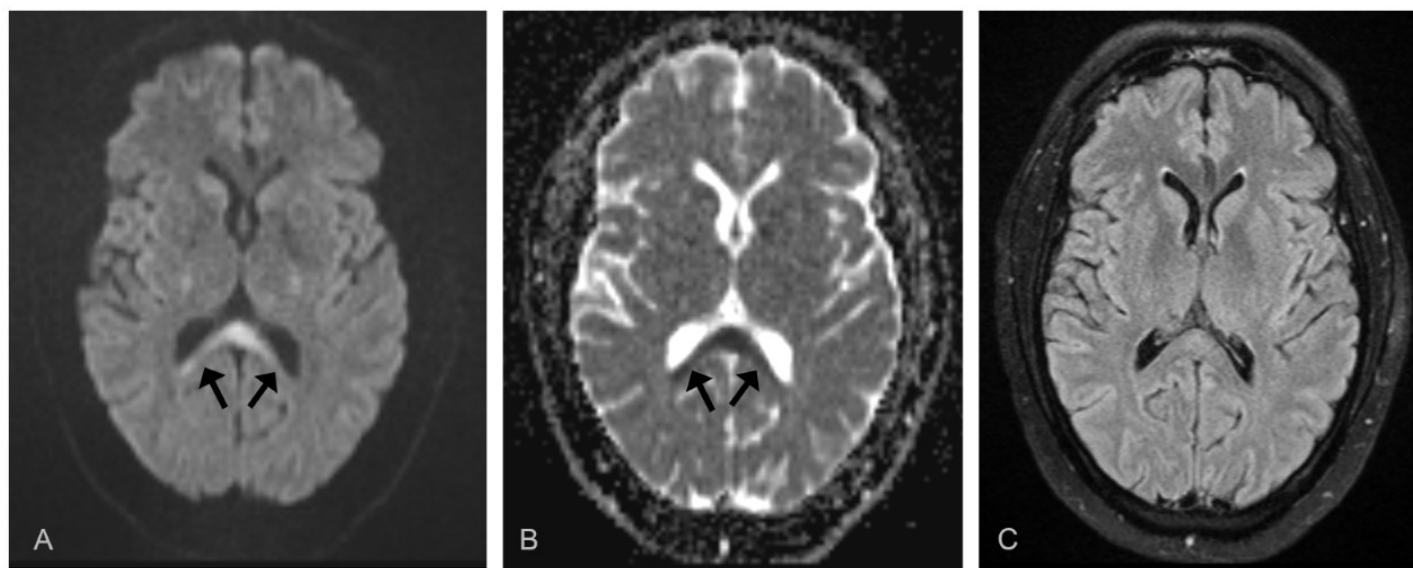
MRI Stroke protocol done on admission. (A) Fluid-attenuated inversion recovery (FLAIR) Imaging demonstrating symmetric, bilateral white-matter lesion in the splenium of the corpus callosum. (B) Apparent diffusion coefficient (ADC) imaging similarly demonstrating symmetric, bilateral white-matter lesion in the splenium of the corpus callosum. (C) Diffusion-weighted imaging (DWI) without any abnormal findings.
